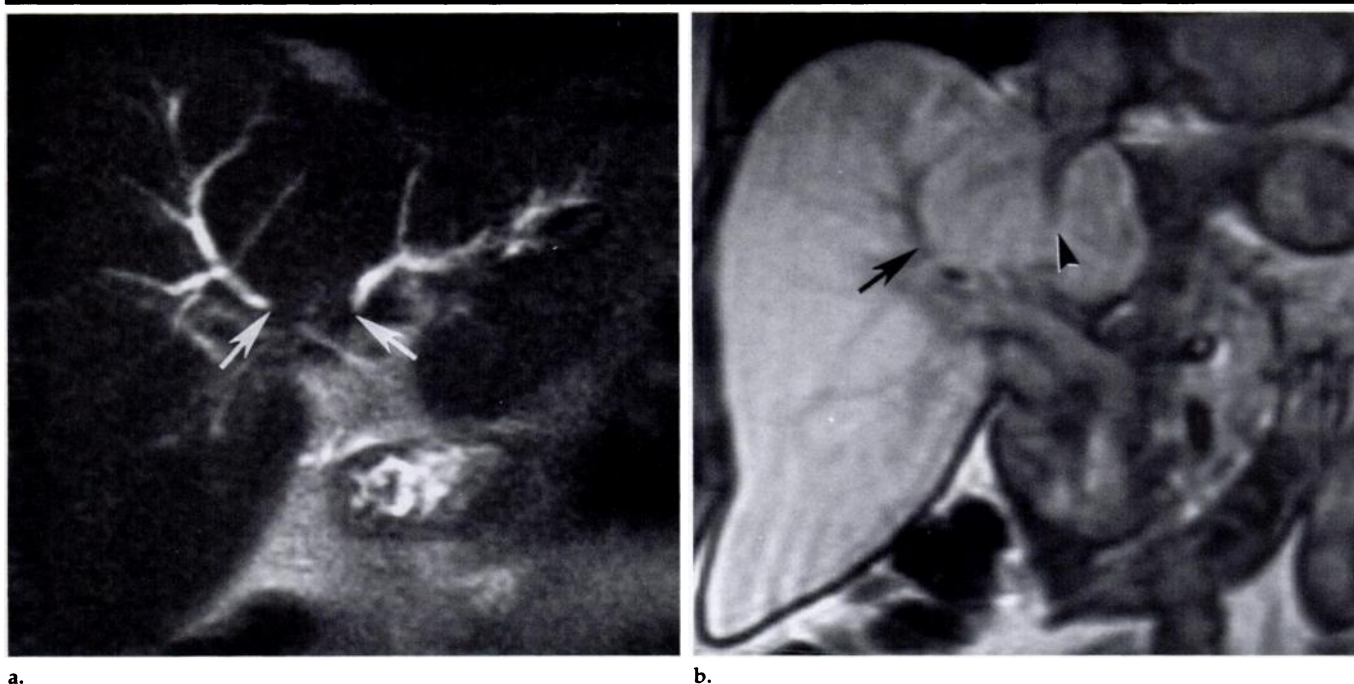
Unresectable hilar cholangiocarcinoma in a 67-year-old man with painless jaundice. (a) MRCP image shows proximal extension of hilar cholangiocarcinoma to involve the right and left hepatic ducts (arrows), which made the disease unresectable. (b) Gadolinium-enhanced coronal T1-weighted gradient-echo image shows the dilated right hepatic duct (arrow) and a portion of the left hepatic duct (arrowhead) but no evidence of hepatic extension of tumor.
